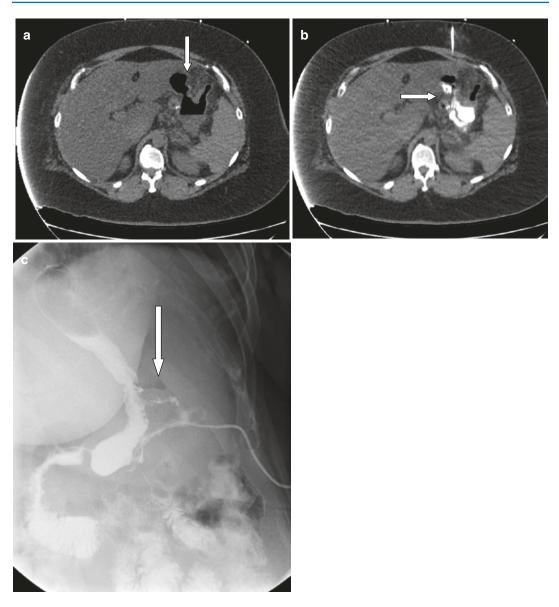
(a-b) shows a CT scan showing gas within postoperative collection before and during percutaneous catheter drainage. (c) shows corresponding contrast study
